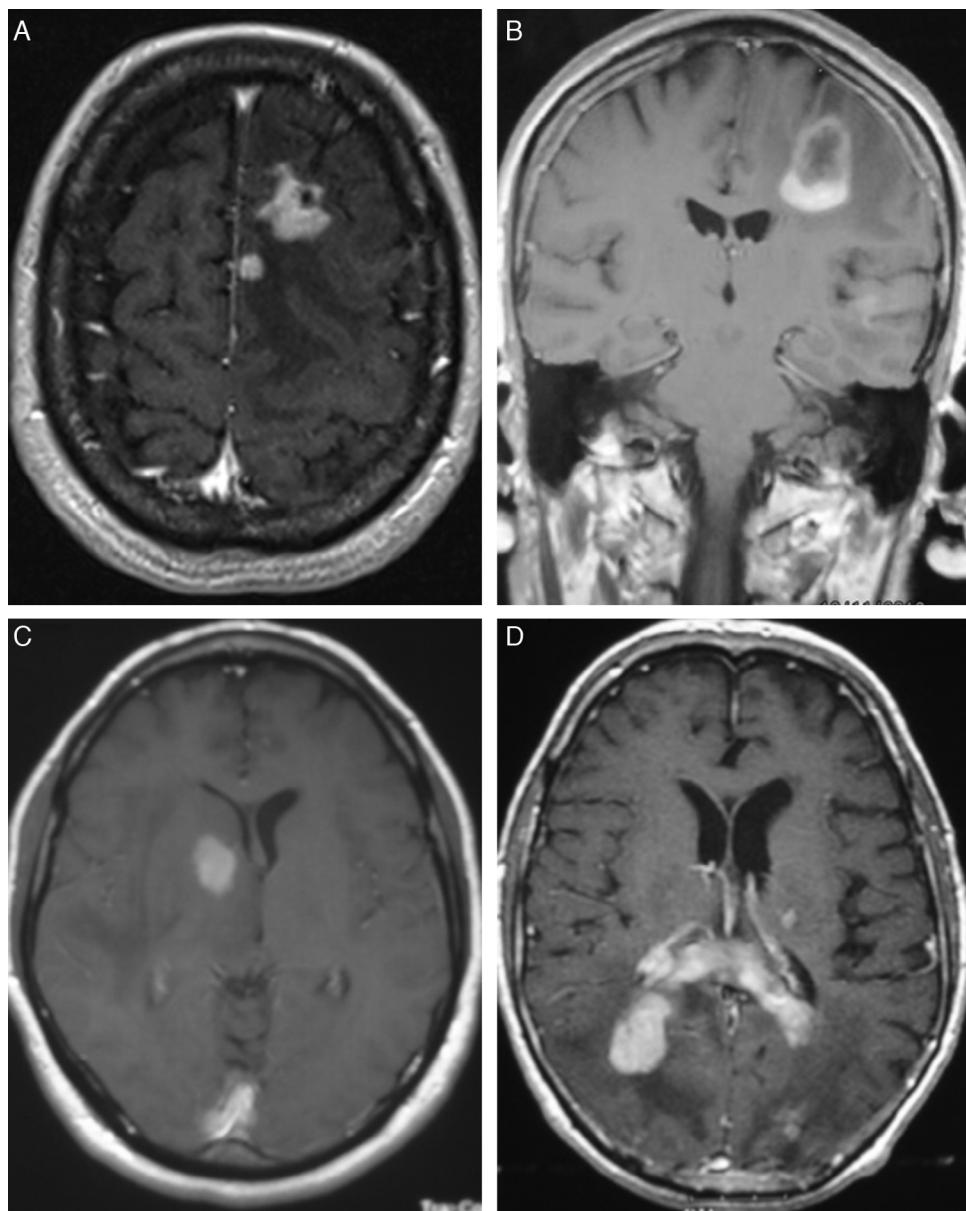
Different gadolinium uptake patterns seen in T1-weighted MRI sequences with contrast enhancement. (A) Lesions adjacent to pia mater plane. (B) Single lesion. (C) Tumour in caudate nucleus. (D) Infiltration of the corpus callosum.
